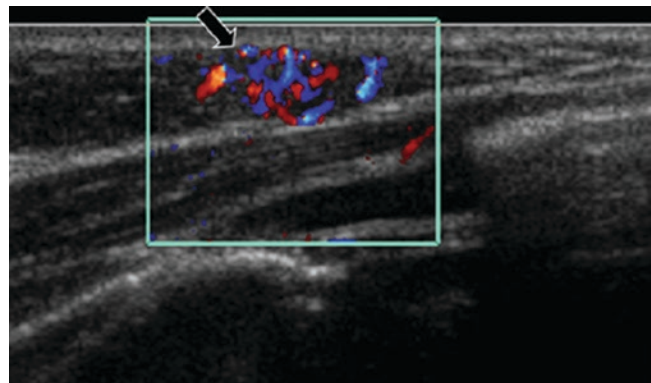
A 2-year-old girl who presented with a palpable right-sided chest wall lesion. Ultrasound shows a subcutaneous soft tissue mass (*arrow*) with increased internal vascularity, consistent with hemangioma
